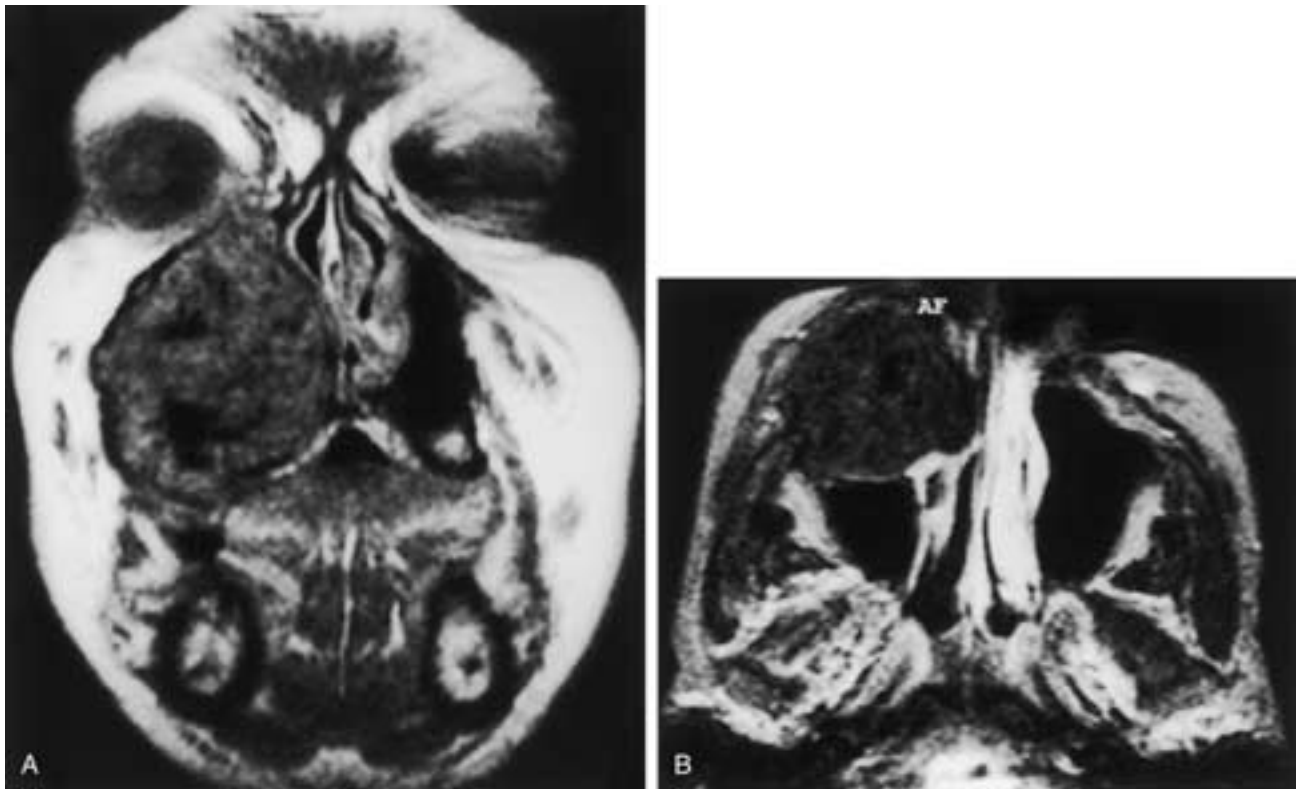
Central cementifying ossifying fibroma. A, Coronal T1-weighted MR image reveals heterogeneous hypointensity and the lesion became even more hypointense on the T2-weighted image (B).
